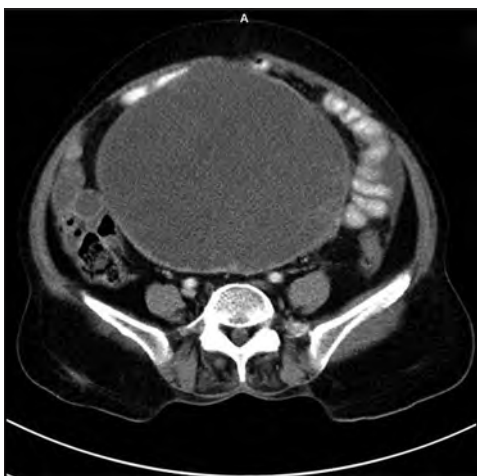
Contrast enhanced CT axial images showing large hypodense lesion with enhancing solid component peripherally and few septations within in the lower abdomen
